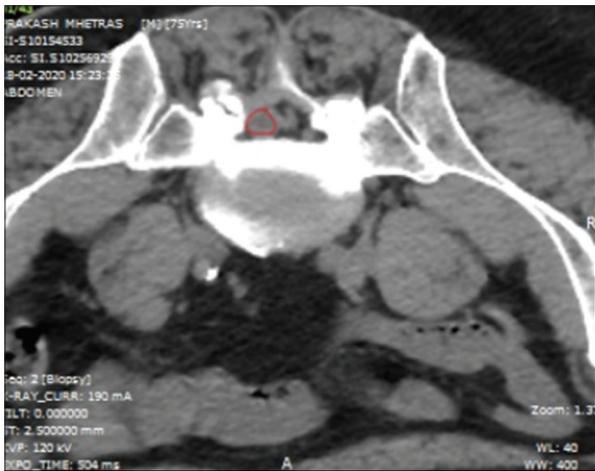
Screening computed tomography scan showing left L4-5 facet cyst (outlined in red)
